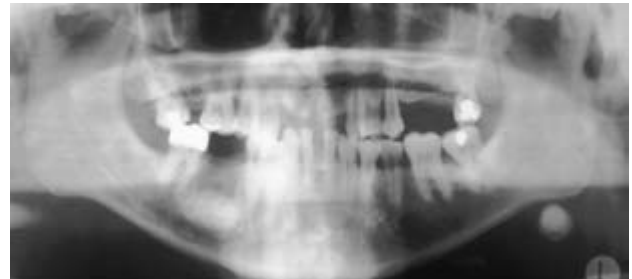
This panoramic radiograph close-up shows two sialoliths within the left submandibular gland.
